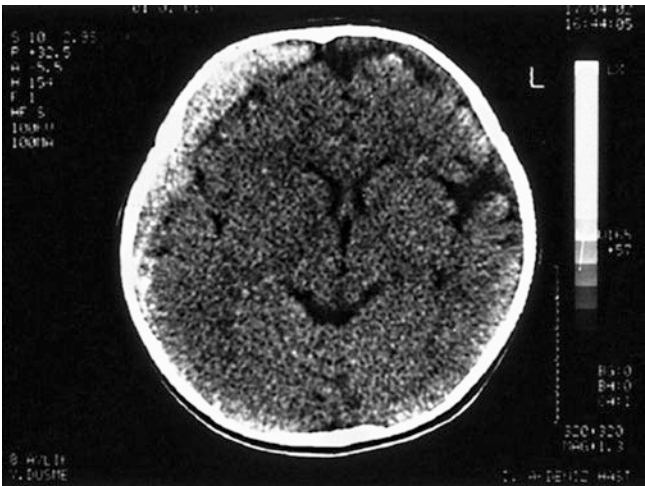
Non-contrast head CT demonstrating an acute subdural hematoma. (From Erdogan B, et al. *Hemispheric cerebrovascular venous thrombosis due to closed head injury*. *Childs Nerv Syst*. 2004;20:239. ▶ <https://doi.org/10.1007/s00381-003-0845-7>. Reprinted with permission from Springer Nature)
